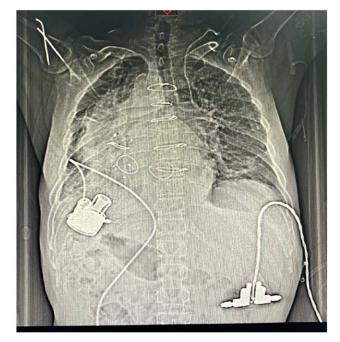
Postoperative chest X-rays showed the VAD pump head located in the right thoracic cavity, along with the replaced aortic valve, tricuspid valve, and the annuloplasty ring for the mitral valve. VAD, ventricular assist device.
